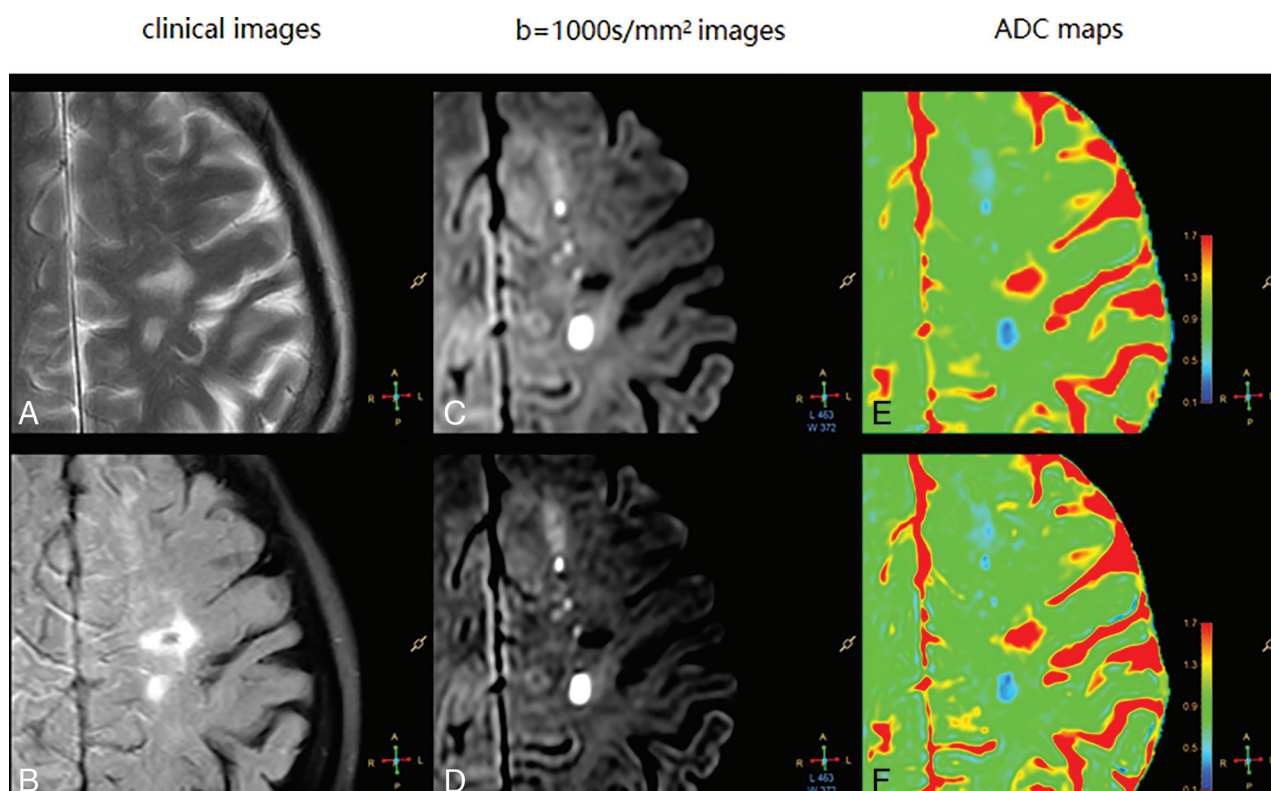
(A) T2WI and (B) FLAIR image for assessment of an acute cerebral infarction in a 70-year-old female patient. (C–D) DWI ($b = 1000 \text{ s/mm}^2$) for DWI_{CS} image and DWI_{DL} image, respectively; (E–F) ADC maps for DWI_{CS} and DWI_{DL}, respectively.
